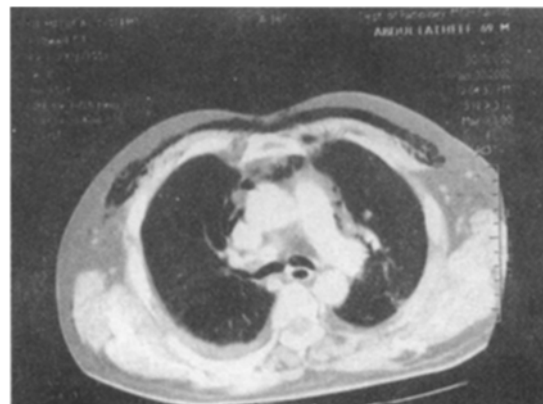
Follow up CT Scan showing fully inflated lungs.
